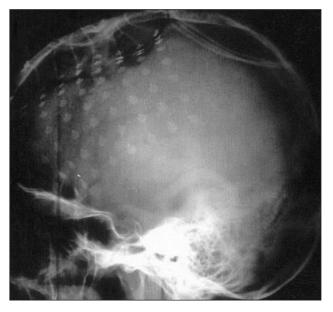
Lateral cranial X-ray showing the subdural grid electrode.
